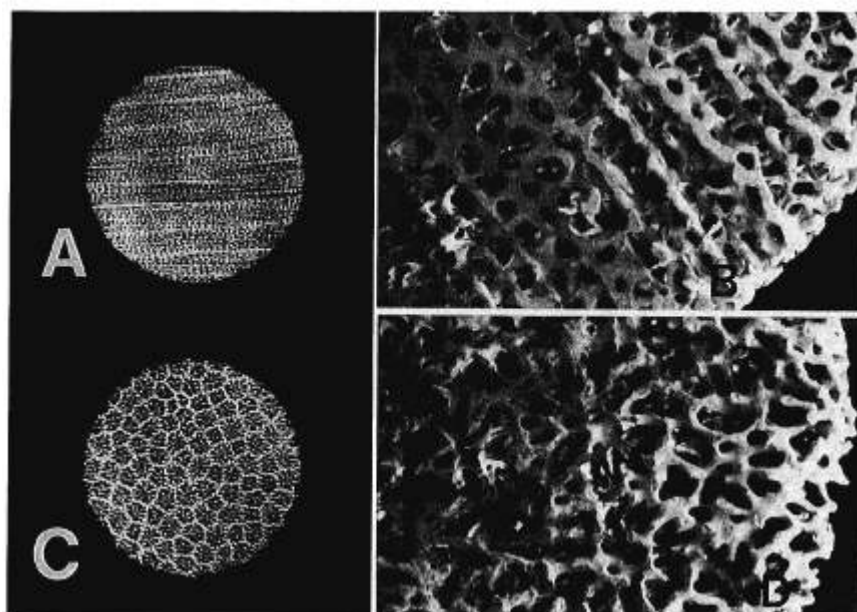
Physical characteristics of porous hydroxyapatite disks before implantation. (A and B) Radiograph and scanning electron images of a disk in which the original coral structure was cut in the longitudinal plane, along the scleroseptal channels of the corallites. (C and D) Disk cut in the transversal plane, showing the "rosette-like" pattern formed by individual corallites. Note interconnectivity of porous spaces in both geometric configurations.
